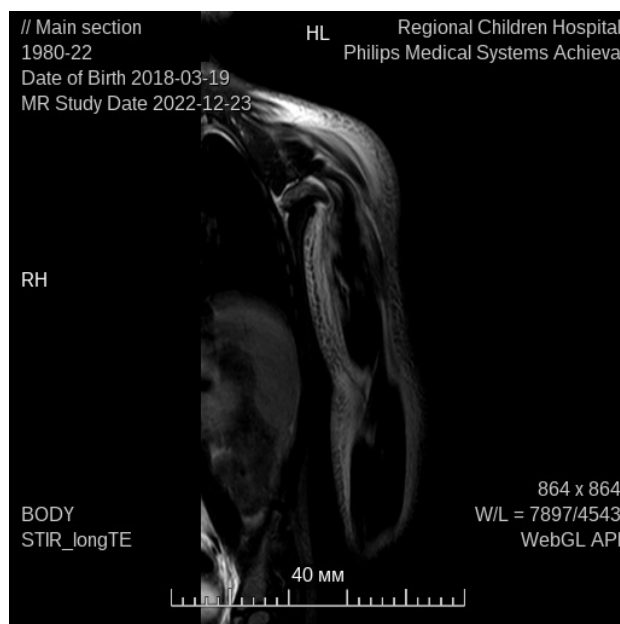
MRI of the left shoulder. Extensive swelling of muscles and interfascial spaces with fluid accumulation
